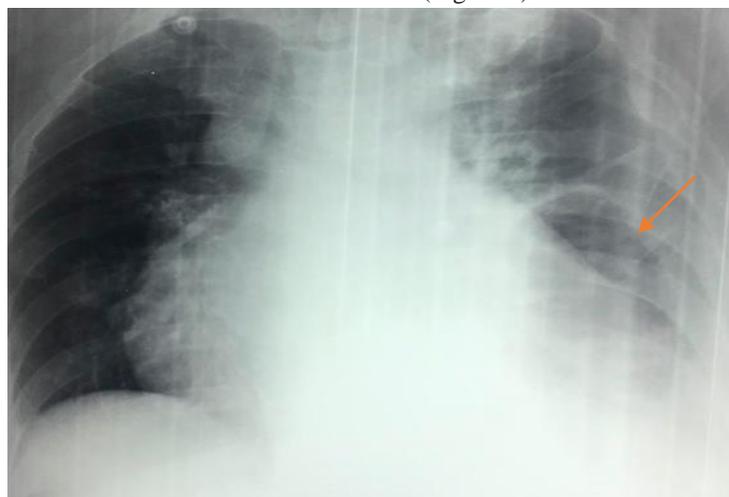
Chest X-ray showing left lung cavity with an air fluid level and a moderate left pleural effusion
